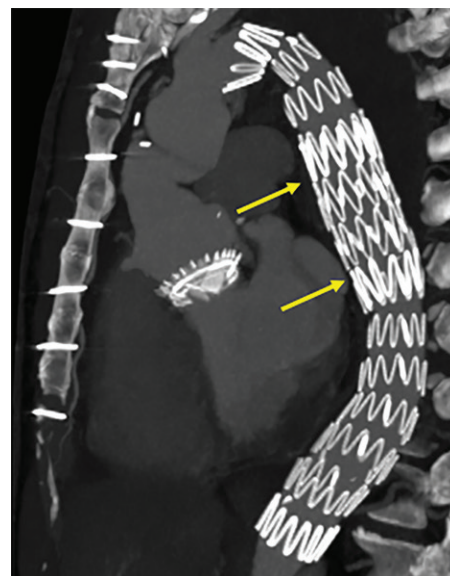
Endovascular stent-grafts in a 54-year-old man after combined proximal and descending aortic repair. Oblique sagittal MIP CT reconstruction shows the nitinol struts of the stent-grafts to advantage. In the mid descending aorta, a second stent with overlapping struts is present (arrows). This was placed to treat an endoleak.
